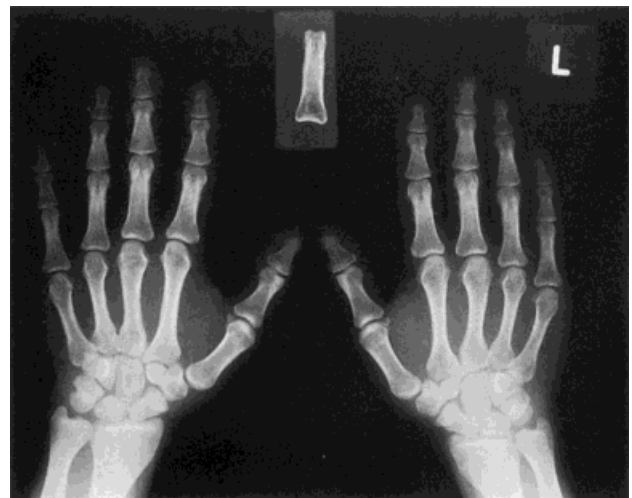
Antero-posterior radiographs of the hands of the probanda's son at the age of 21 years. The tubular bones are shortened but not dysplastic.
